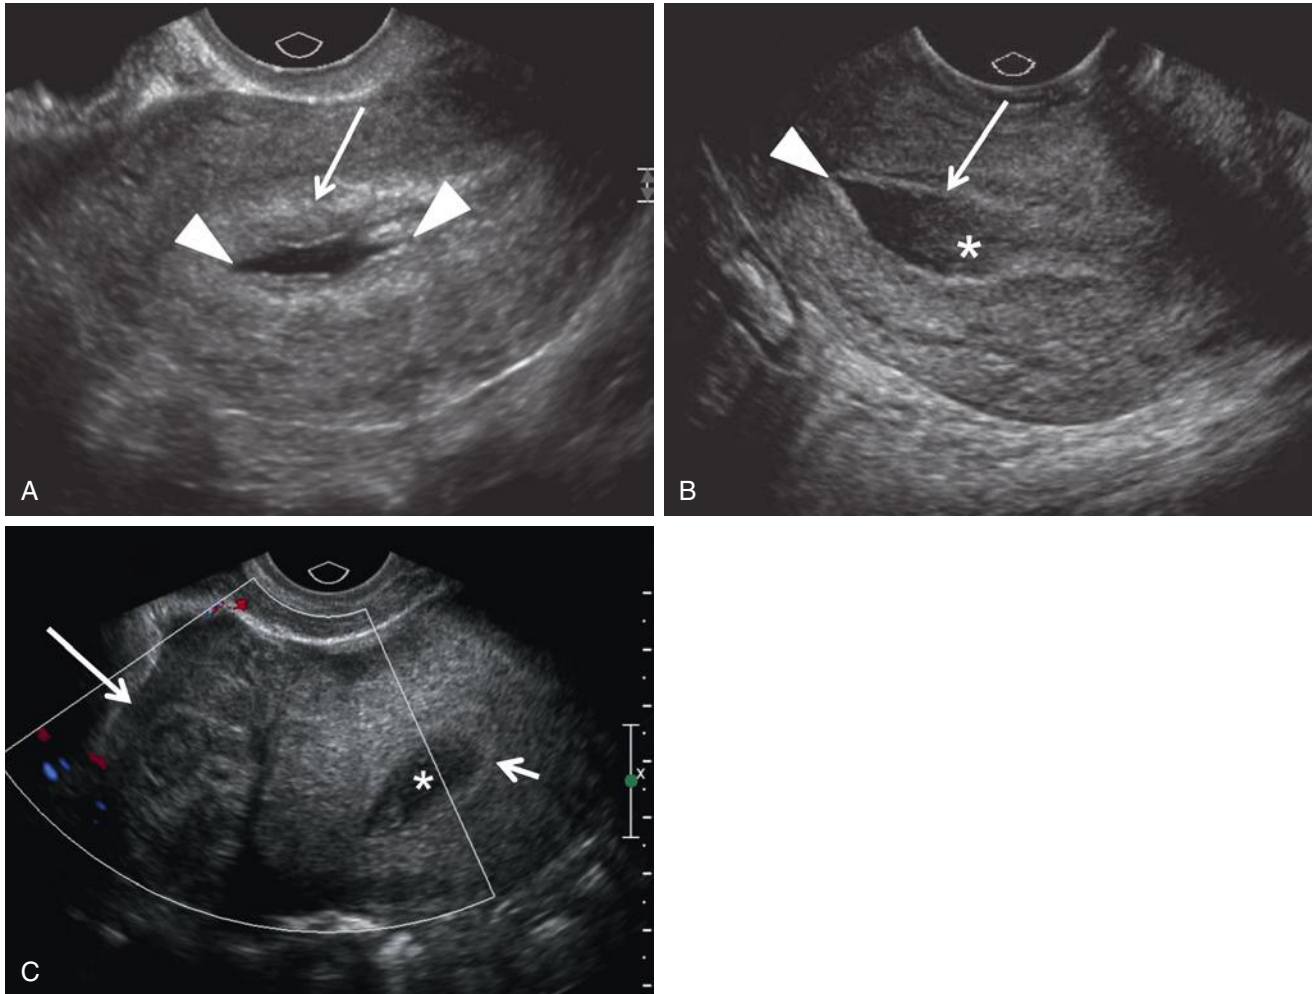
Intrauterine fluid associated with EP, referred to as *pseudogestational sacs*. A, Transvaginal sagittal scan of the uterus demonstrating an oblong intrauterine fluid collection with pointed margins (*arrowheads*) surrounded by a single decidual lining (*arrow*). There was an adnexal tubal ectopic pregnancy (not shown). B, Transvaginal scan of another patient with fluid in the endometrial canal with pointed edge (*arrowhead*). Intraluminal echoes (*asterisk*) represent blood, surrounded by single thin decidual lining (*arrow*). The patient had an ectopic pregnancy (not shown). C, Transvaginal color Doppler scan of a third patient demonstrating a right adnexal ectopic pregnancy adjacent to the uterus surrounded by a large hematoma (*long arrow*). The ectopic pregnancy demonstrates no blood flow on color Doppler interrogation. Fluid-containing low level echoes (*asterisk*) consistent with hemorrhage is noted centrally within the endometrial cavity. The fluid is surrounded by a single echogenic rim of decidual tissue (*short arrow*). This appearance has been referred to as a *pseudogestational sac*. However, most authors now prefer to avoid this potentially confusing terminology and use of this phrase is discouraged.
